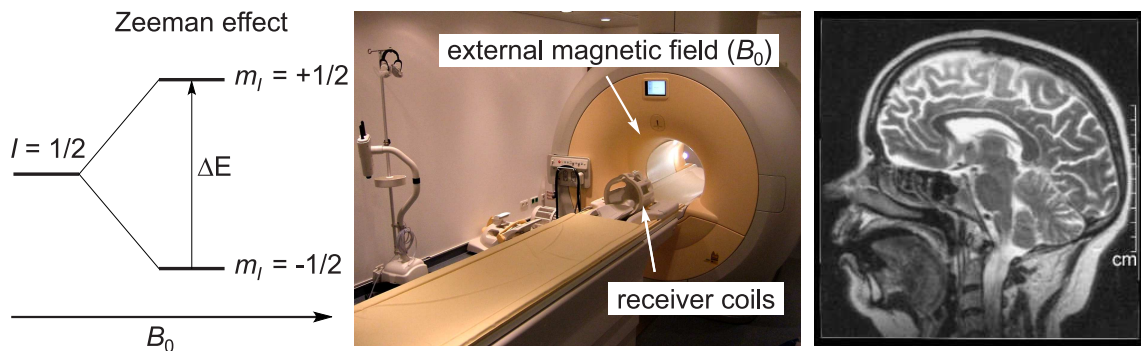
Zeeman effect for an $I = 1/2$ nucleus (left), a clinical 3 T MRI scanner with receiver coils for a human head (middle) and a tomographic image of a human head (right, sagittal plane T_2 weighted).
